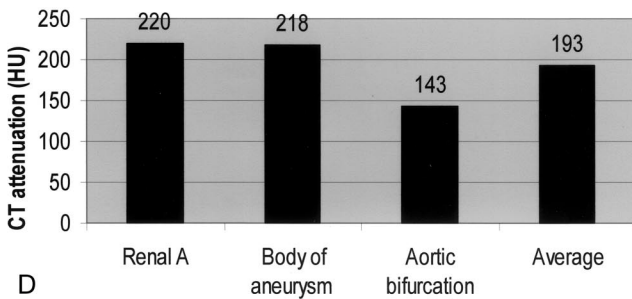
Method of obtaining VIE images by removing contrast-enhanced blood from the abdominal aorta. A–C Three locations were chosen to measure attenuation of the contrast medium at the level of the renal artery, body of the aneurysm, and aortic bifurcation. D Graph shows CT attenuation value at each location and the average value. E After applying the CT number threshold, contrast is removed from the aorta and endoluminal flythrough can be performed (arrow).
